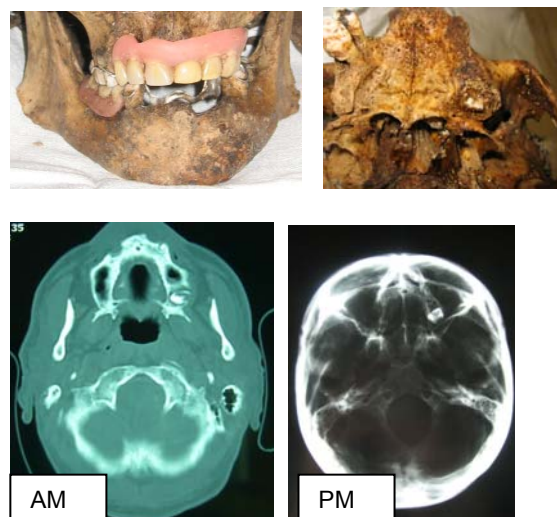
Top - the jaws with both prostheses and the left third molar retained in the bone and severely destroyed by caries. Bottom - on the left, the last radiograph of the CT scan of the missing person's skull, on the right, a direct x-ray of the skeleton's skull.
